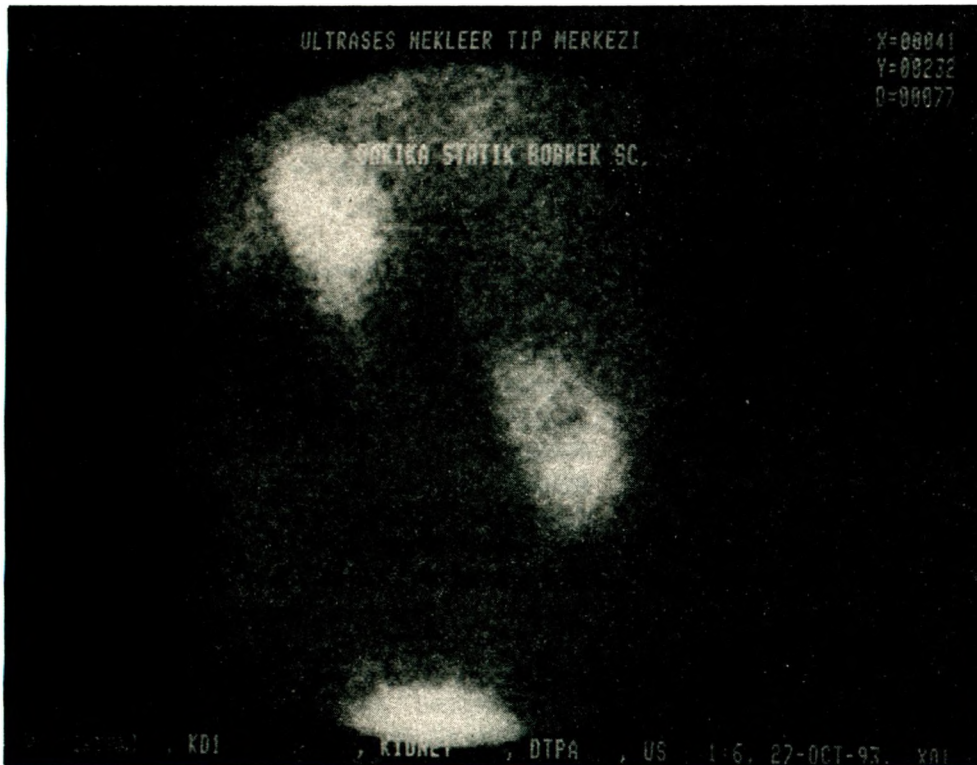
Renal scintigraphy showing left kidney misinterpreted as spleen
